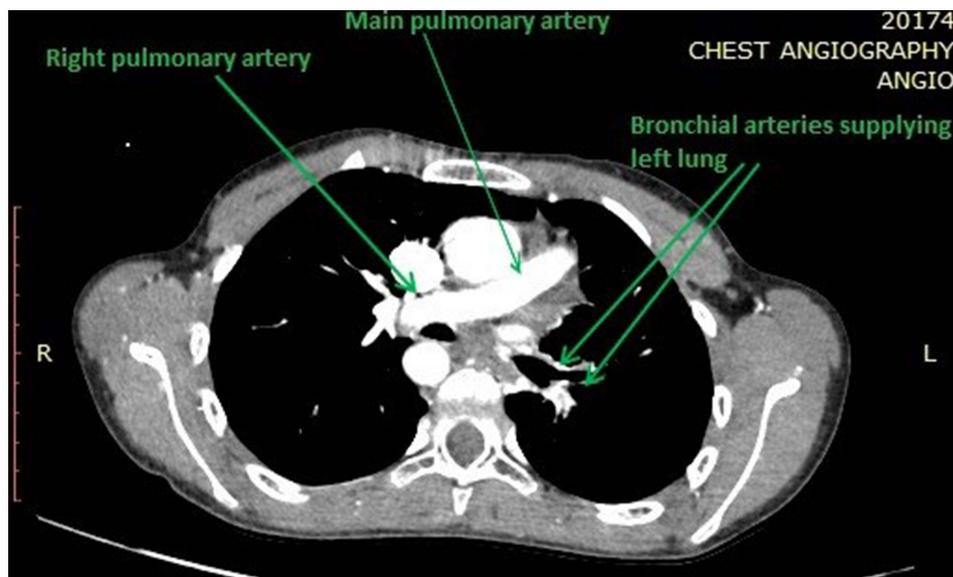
Chest CT scan showing continuation of main pulmonary artery as right pulmonary artery and absence of left pulmonary artery and left lung supplied by collaterals.
